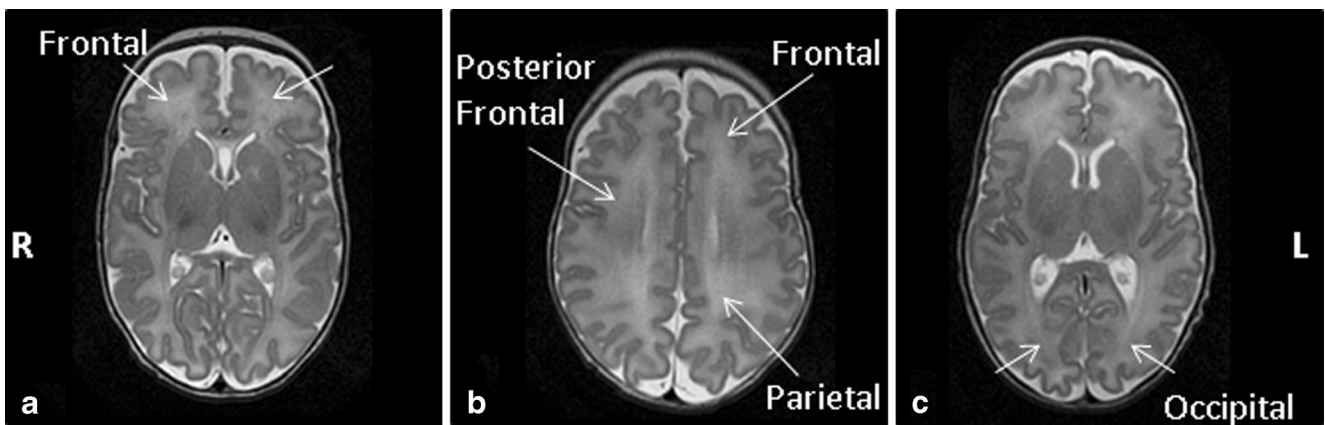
Regional assessment of DEHSI on MRI: a frontal region, b posterior frontal and parietal regions, c occipital region. The DEHSI in these images was classified as mild
